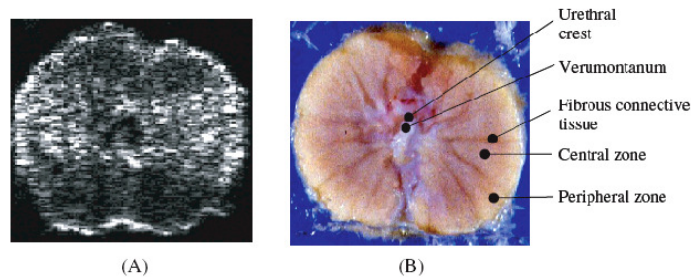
Sonogram of (A) an *in vitro* canine prostate and (B) its corresponding anatomy
